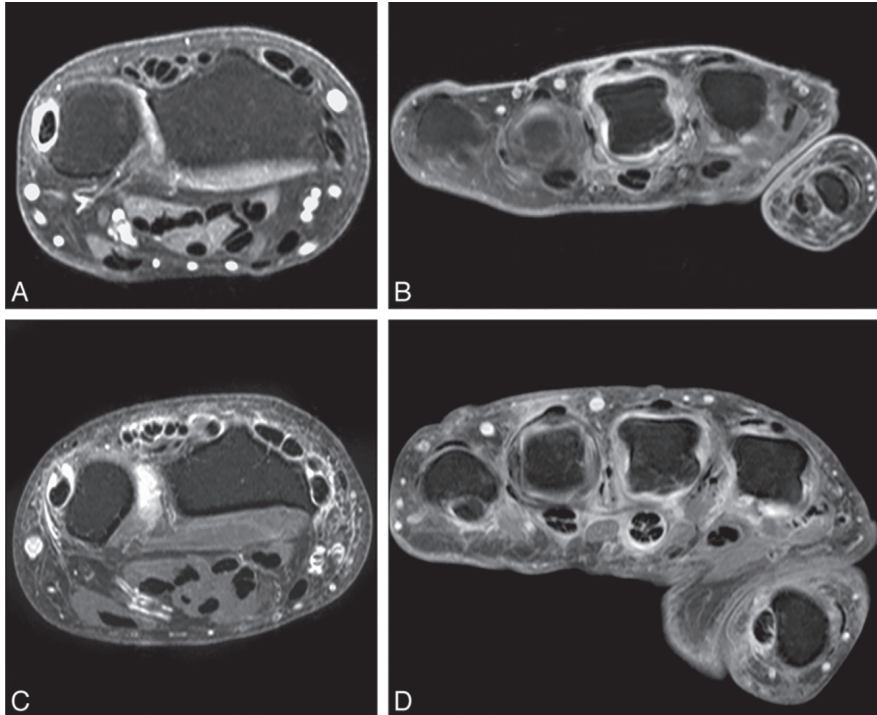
Axial T1 post-gadolinium, fat-saturated magnetic resonance images (MRIs) at the level of the metacarpophalangeal (MCP) joints and wrist. MRIs of symptom-free control (A), a patient with clinically Suspect Arthralgia (CSA; B), and a patient with RA (C-D) are shown. In this symptom-free person a high tenosynovitis intensity is depicted at the extensor carpi ulnaris (A). In the CSA patient, synovitis and peritendinitis are pronounced at the MCP3 joint (B). The patient with RA has MRI-detected tenosynovitis in the extensor compartments of the wrist (C) and clear synovitis and tenosynovitis at the level of the MCP3 joint (D).
